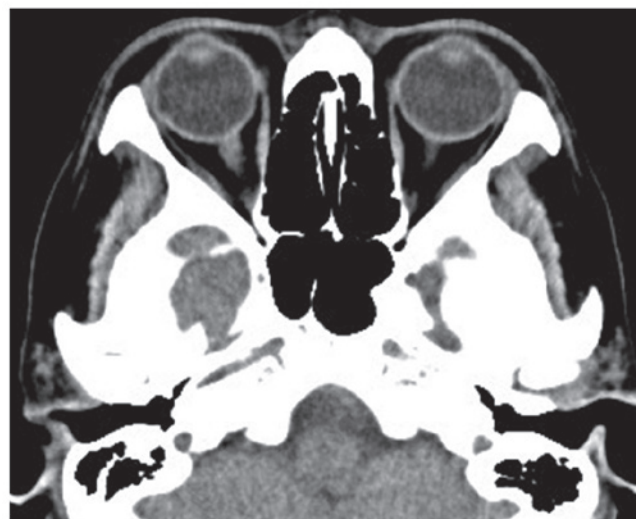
Brain computed tomography scan following two cycles of bevacizumab-containing chemotherapy revealed the disappearance of the choroid tumor in the left eye.
